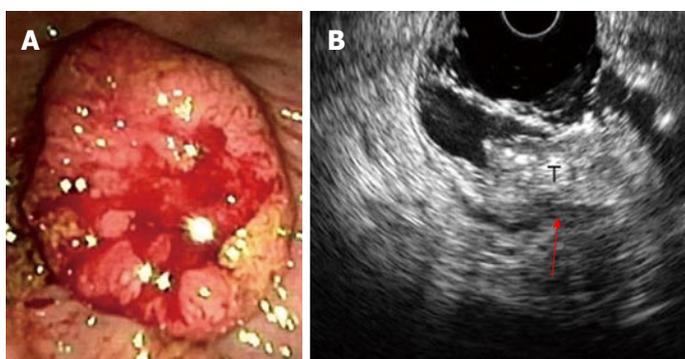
Stage T3 rectal cancer: (A) endoscopic and (B) ultrasonographic view. Endoscopic ultrasound with radial array transducer UM160 (5-20 MHz), showing increased wall thickness for the presence of a mass with inhomogeneous echogenicity, invading all the layers of the wall and minimal infiltration of the perirectal fat. T: Tumor; Red arrow: Infiltration of the perirectal fat.
